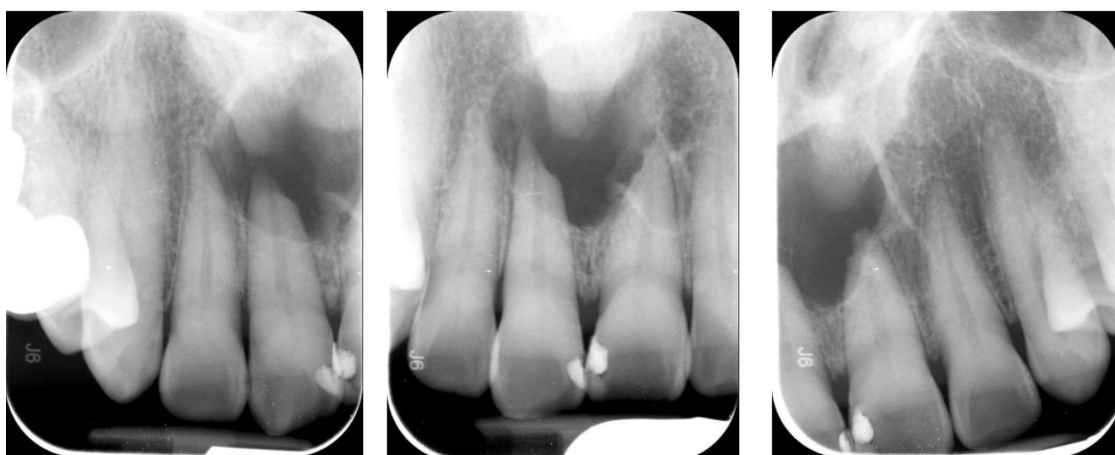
Radiographic images 20 days post-surgery showed that the lesion size and density is unchanged, and no additional root resorption is observed.
